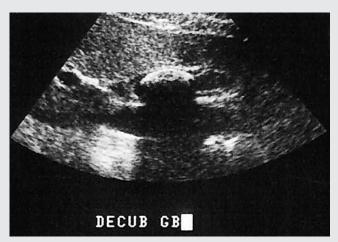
Transverse sonogram of the gallbladder.
